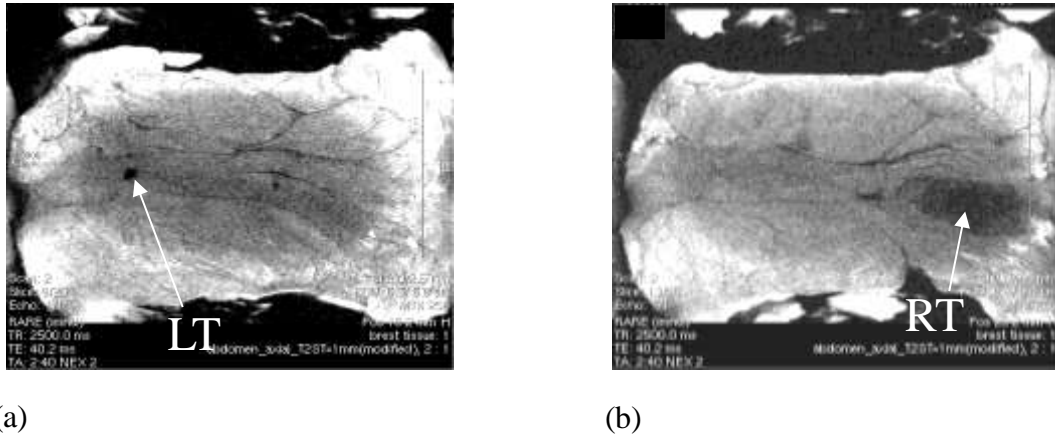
Magnetic resonance images of the left tumor and the right tumor pieces (LT: left tumor, RT: right tumor)
